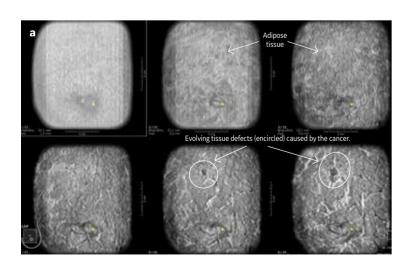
a,b. Placing the cursor over the tissue defect (a) produces a reconstructed 2D ultrasound image, showing the larger malignant tumor (b).
